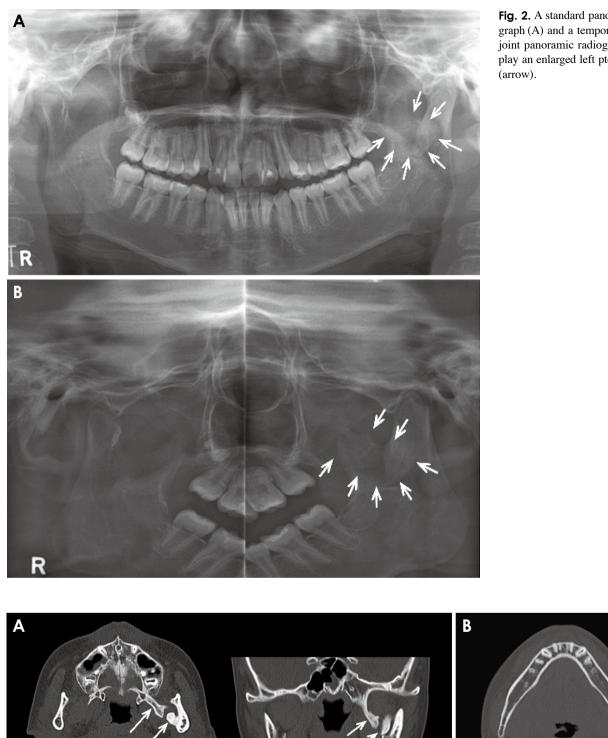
A standard panoramic radiograph (A) and a temporomandibular joint panoramic radiograph (B) display an enlarged left pterygoid plate
